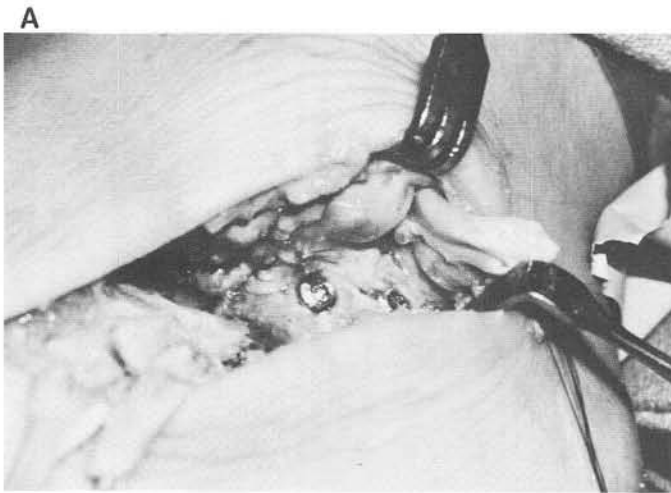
Two compression screws are used to fixate main lateral fragment of posterior facet. A. Intra-operative appearance of compression screws is seen. B. Axial radiograph of same fracture seen in 29A.
